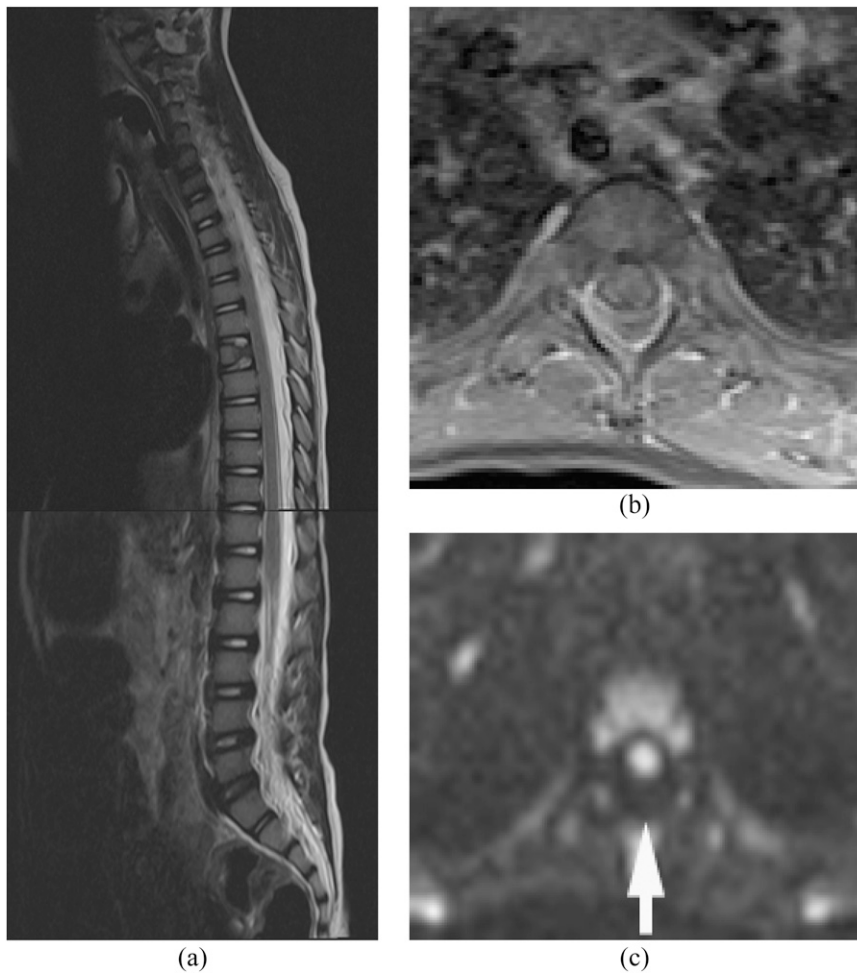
Ruptured epidermoid with chemical meningitis. (a, b) Sagittal MRI shows a large T_2 hypointense (a) and T_1 hyperintense (b) mass with posterior scalloping of the vertebral bodies. (c) Diffusion-weighted imaging demonstrates slight hyperintensity (not shown) in the mass with decreased apparent diffusion coefficient (arrow).
